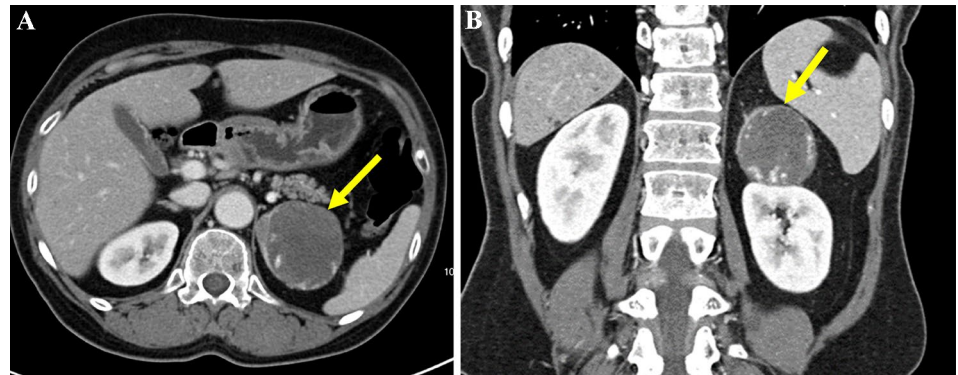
Cystic pheochromocytoma. Axial (A) and coronal (B) CT showing a 10 cm complex cystic left adrenal mass (arrow) in a patient who presented with history of headache, palpitations, hypertension, diaphoresis, and elevated metanephrine levels. Symptoms resolved after adrenalectomy
